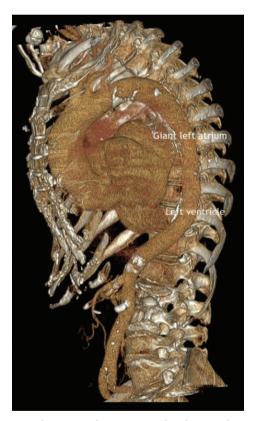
Computed tomography reconstruction images demonstrating the giant left atrium and small left ventricle.
